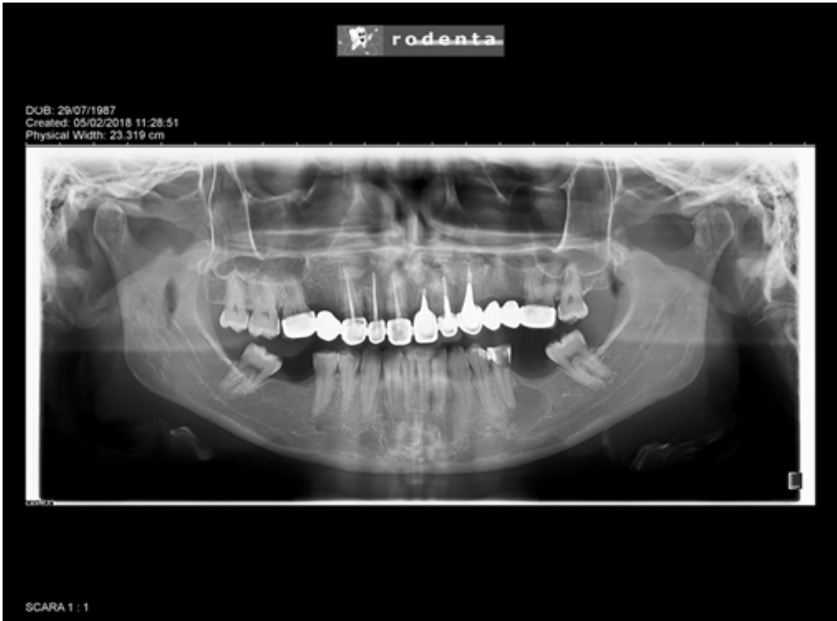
Orthopantomography –1.6 molar present.
